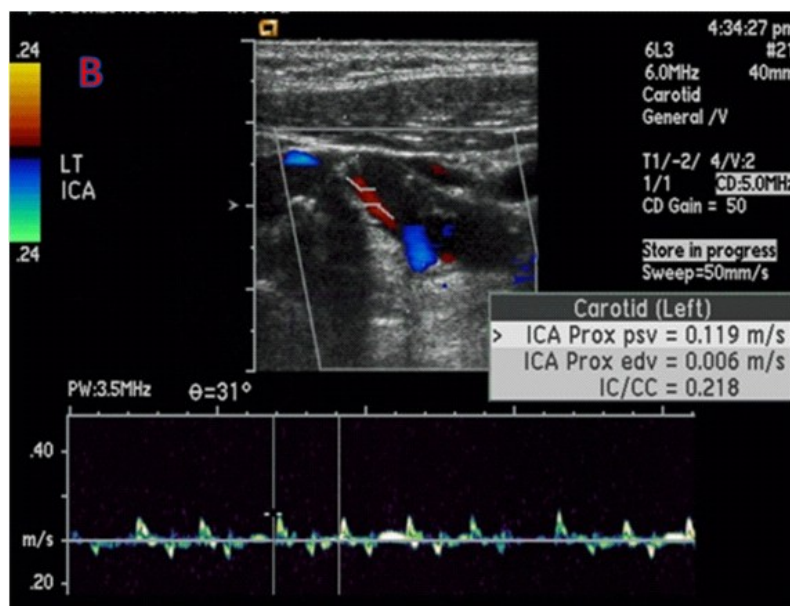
The string sign of the internal carotid artery on duplex ultrasonography — a long, tapered, markedly narrowed residual lumen. Ultrasound is operator-dependent and insensitive to high cervical and non-occlusive dissection, so a normal scan cannot exclude the diagnosis.
